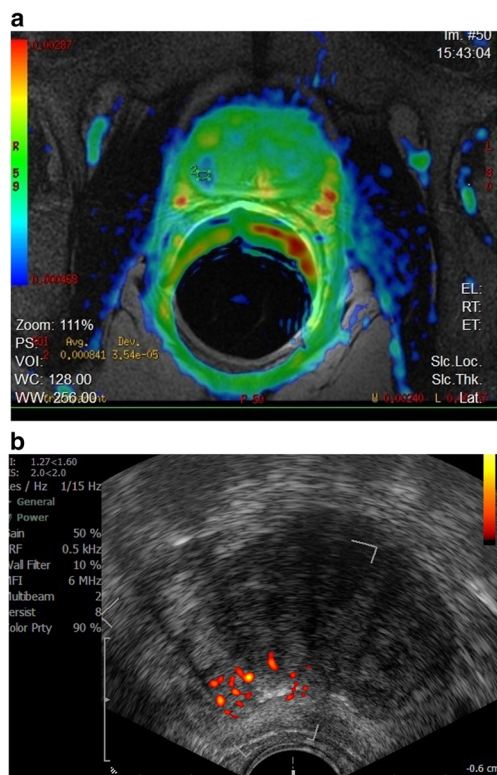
a Highly susp. MRI b Highly susp. MRI and PDS
